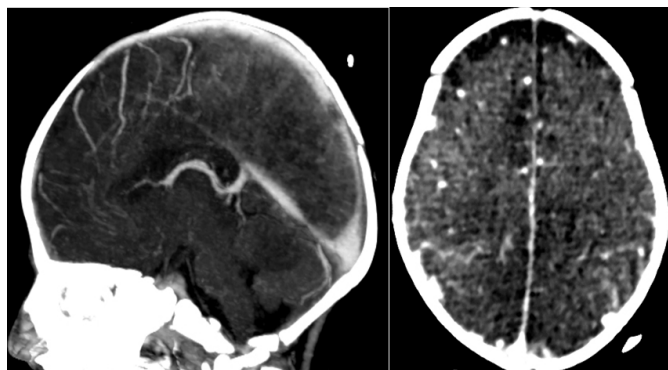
Cerebral CT scan showing diffuse ischemia with upper longitudinal sinus thrombosis.
